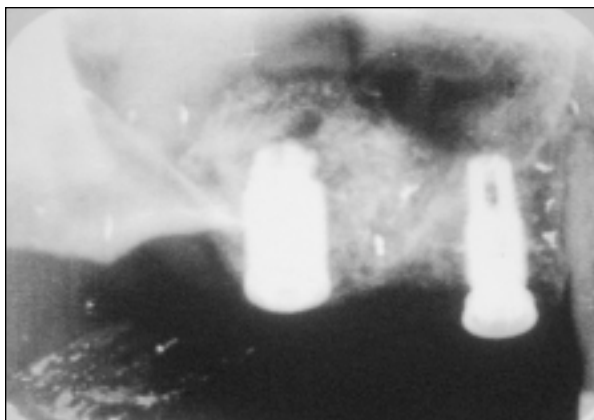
Immediate postsurgical intraoral radiograph demonstrating the obtained sinus lift.
